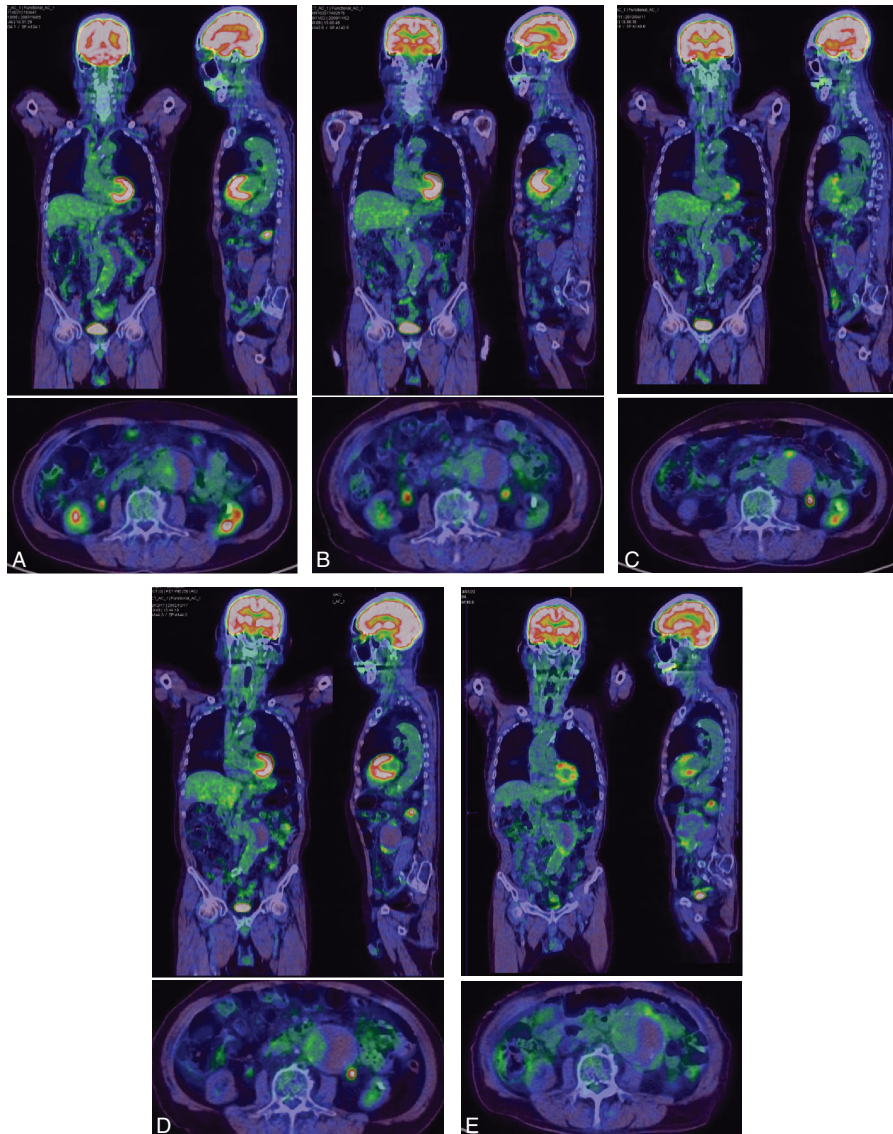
Coronal, sagittal, and axial sections of ^{18}F -FDG-PET scans fused with CT scans of a patient with a juxta-anastomotic abdominal aortic aneurysm over a 7-year follow-up period obtained in October 2007 (A), November 2009 (B), April 2012 (C), December 2012 (D), and January 2014 (E). High focal ^{18}F -FDG uptake along with the implanted graft (A–C) shifted to the bottom of the aneurysm sac (D), and it extended to the entire aneurysmal wall before the rupture and patient's death (E). ^{18}F -FDG = ^{18}F fluoro-deoxyglucose, CT = computed tomography, PET = positron emission tomography.
